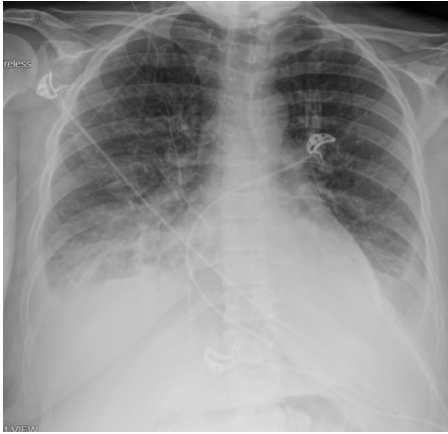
A chest x-ray during third day of admission showing bilateral pleural effusions.
